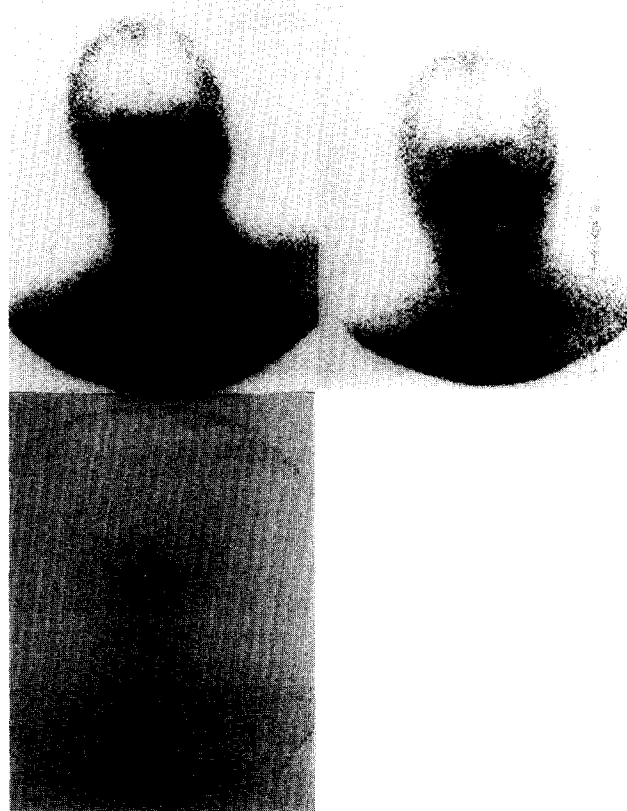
Anterior planar scintigrams at 1, 4 and 22 h, from an adenomatous cancer in the nasal cavity (arrow; patient no. 2).
